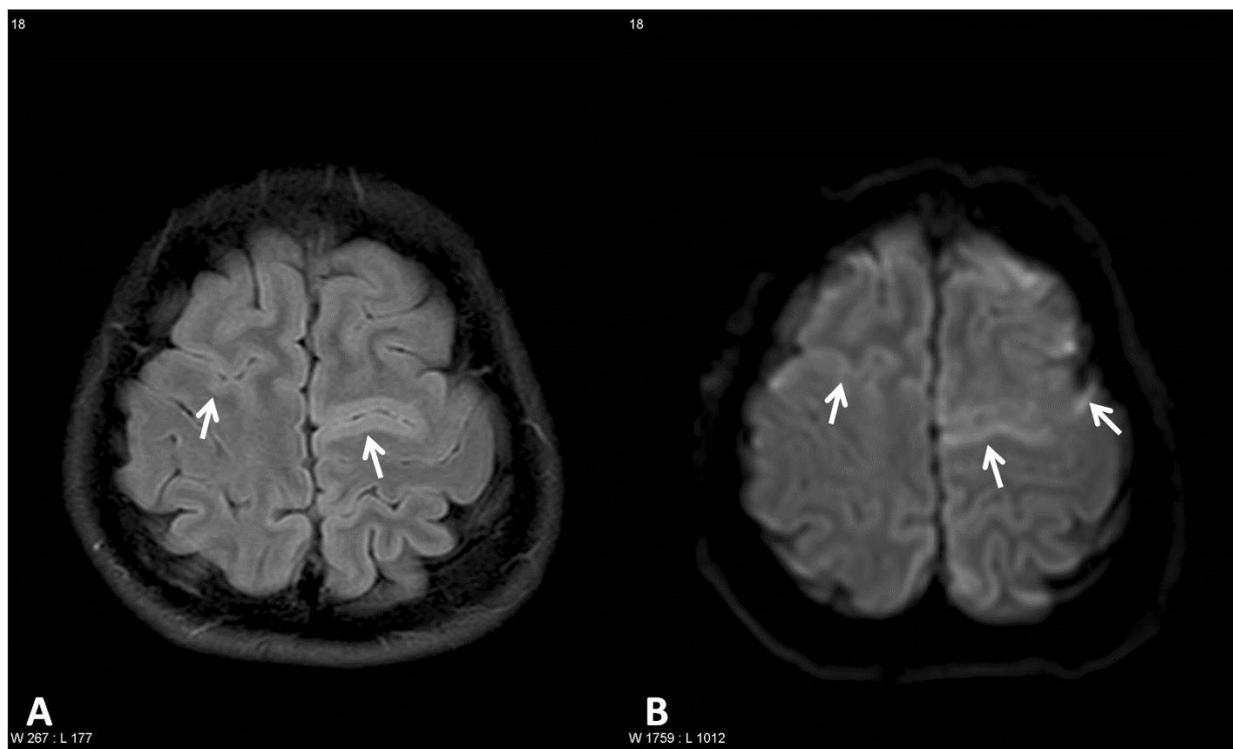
Fluid-attenuated inversion recovery (FLAIR, A) and diffusion-weighted MR images (DWI, B) demonstrate multiple hyperintense lesions in both high frontal cortices (arrows). The lesions are more clearly demonstrated on DWI (B) than on FLAIR image (A).
